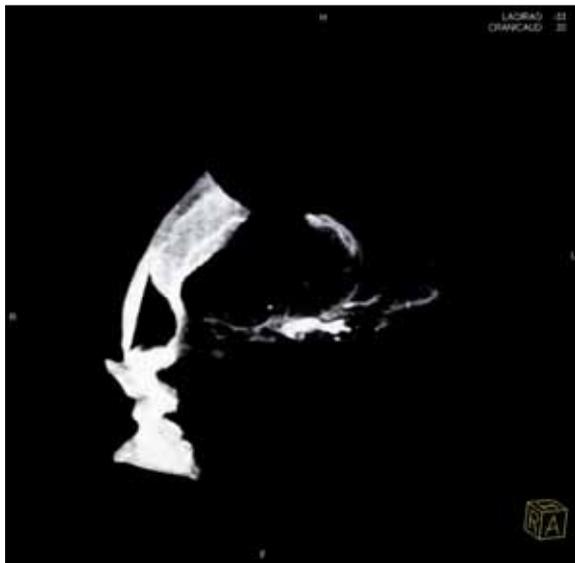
CT angiography showed weak opacification of the middle cerebral arteries (M2 segment) and the anterior cerebral arteries (A2 segment) in early and late phase. External carotid arteries were opacified, indicating that contrast medium had been injected correctly.
